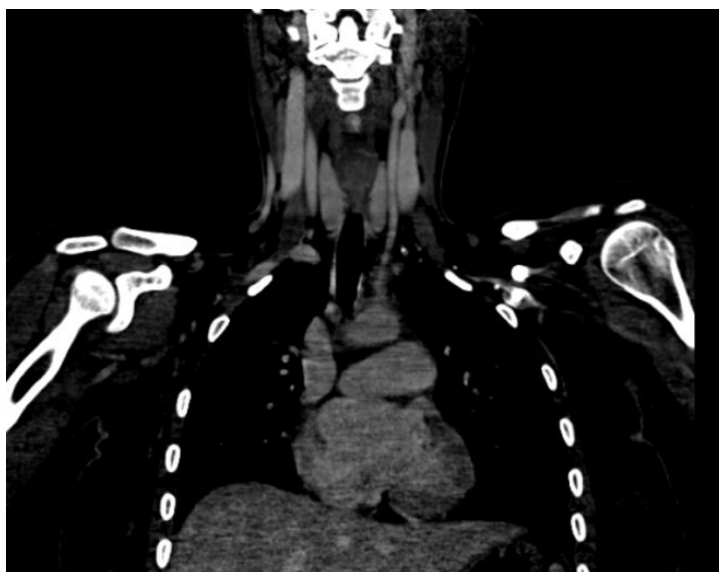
Coronal cervicothoracic CT scan shows left common carotid artery appears narrowed compared to the right, leading to a reduction in its lumen size
